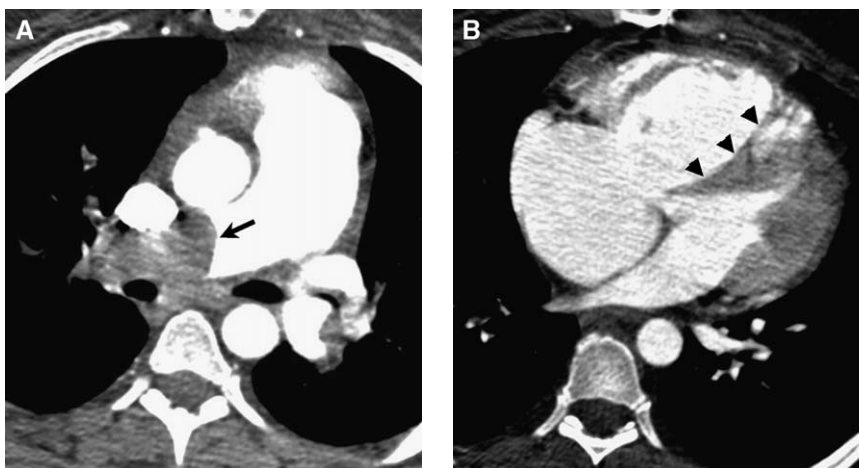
Massive pulmonary embolism. (A) Thromboembolus causes occlusion (arrow) of the right pulmonary artery. A clot burden of this magnitude may cause acute right ventricular dysfunction and reduced cardiac output. (B) Right ventricular dilatation is visible on CT, with displacement of the interventricular septum (arrowheads) toward the left ventricle. A ratio of RV:LV short-axis diameter of 1.5:1 or greater indicates severe right ventricular strain.
